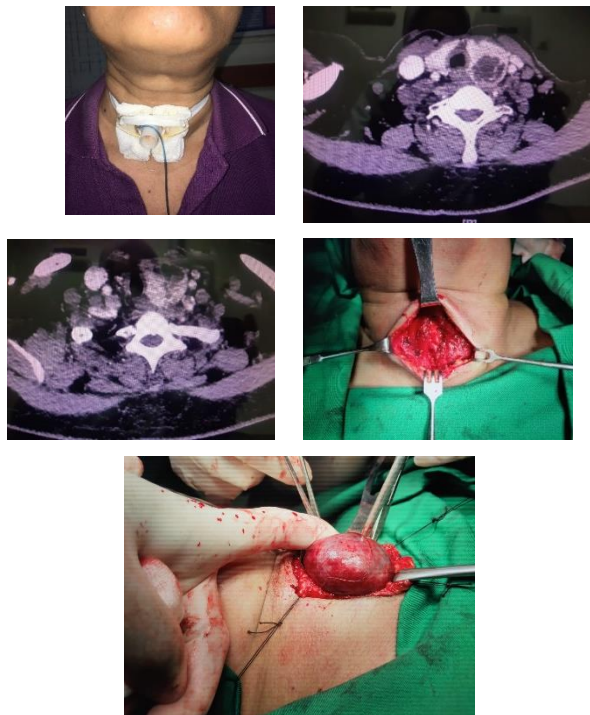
Lump at left thyroid, CT scan and surgery procedure (left hemithyroidectomy)
